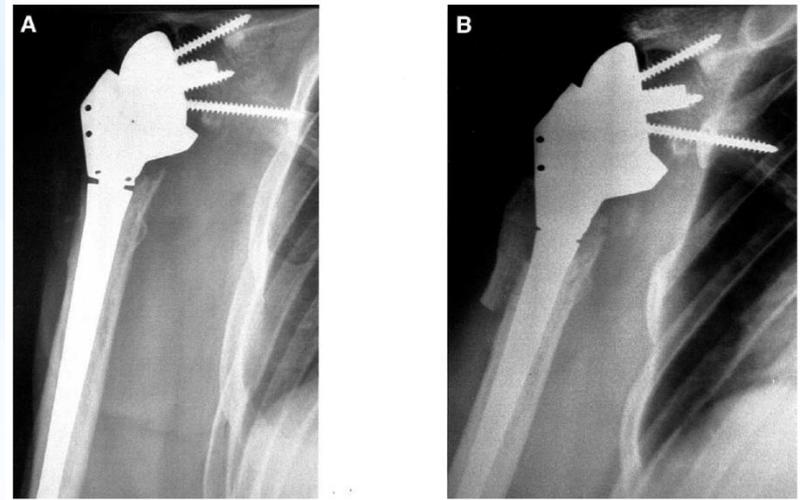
Case 3. A, Unscrewing of humeral diaphysis. B, Radiograph at 6 months after surgery showing partial resorption and partial incorporation of bone graft.
